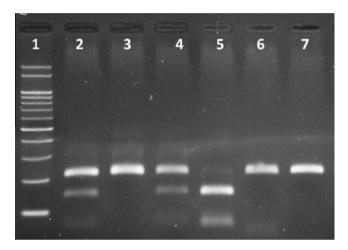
RFLP results of VDR FokI polymorphism. Lanes 1 and 7 represent the 100 bp DNA ladder and undigested PCR product, respectively. Lane 5 shows the CC genotype and Lanes 3, 6 show the TT genotype. Heterozygous CT genotype is shown in lanes 2, 4.
